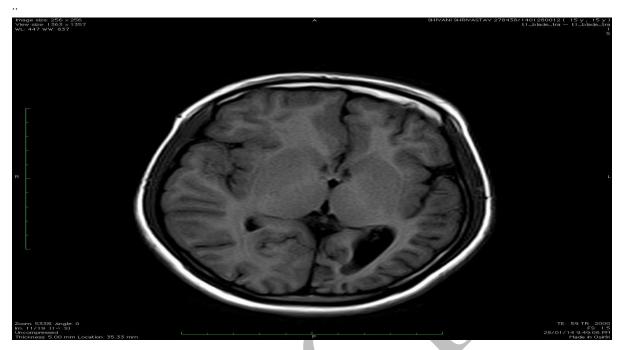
Brain MRI axial T1 image shows atrophy of the entire left hemisphere and calvarial thickening..
